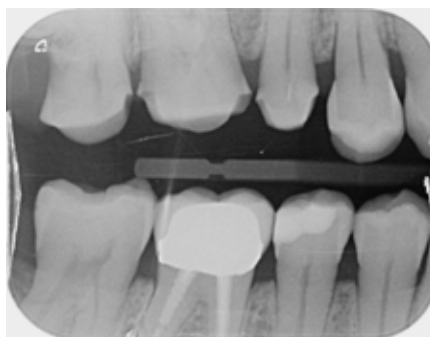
After build-up and preparation. Intraoral view and X-ray
